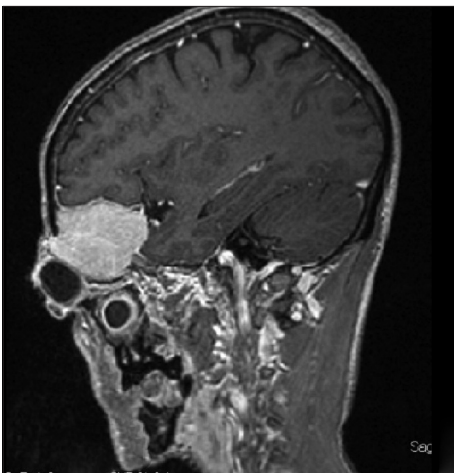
Magnetic resonance imaging scan of skull showing well-defined lobulated mass in extra-axial space in superior quadrant of left orbit (Sag T1)
